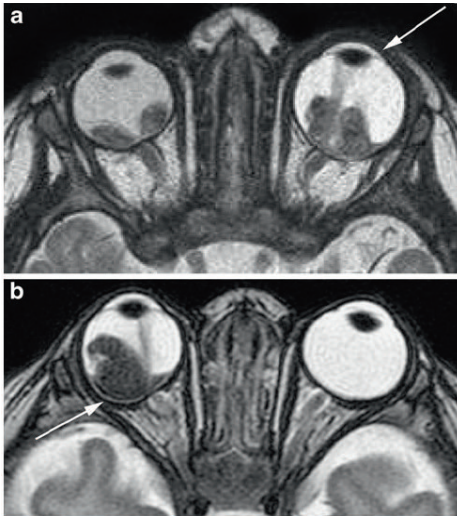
Retinoblastoma with signs of increased intraocular pressure following subretinal hemorrhage (fluid–fluid levels). a Bilateral retinoblastoma with increased size of the left eye (buphthalmus) and a shallow anterior chamber (arrow) seen on T2-weighted (TR/TE, 4,430/102 ms) image. b Bilateral retinoblastoma with focal bulging of the posterior eye segment (arrow) of the right eye and a shallow anterior chamber seen on T2-weighted (TR/TE, 4,430/102 ms) image
